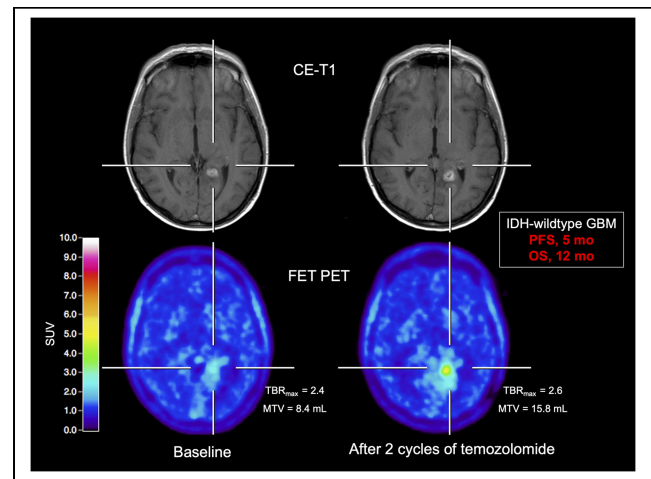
Patient with an IDH-wildtype glioblastoma (GBM) with unfavorable survival (patient 8). After 2 cycles of adjuvant temozolomide chemotherapy, the contrast-enhancing lesion on MRI is slightly enlarged (criterion *progressive disease* according to RANO criteria not fulfilled) compared with baseline MRI (upper row). In contrast, corresponding ¹⁸F-FET PET at follow-up shows relative to baseline scan (bottom row) an increase of metabolic activity as assessed by TBR_{max} and MTV (relative increase, 8% and 88%, respectively). Patient had unfavorable outcome with a PFS of 5 mo and an OS of 12 mo.
